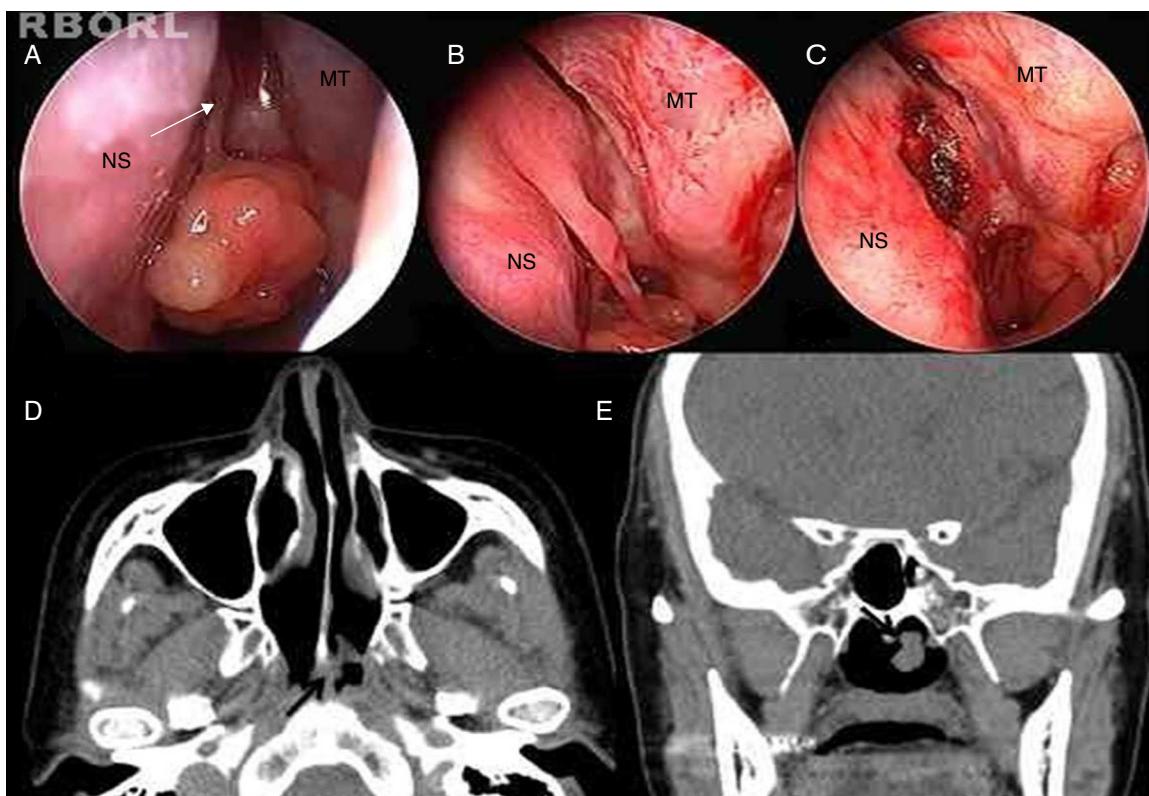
Endoscopic view and PNS CT findings. (A) Close-up view of the nasal polyp based in the left posterior septum (whitish arrow, pedicle; NS, nasal septum, MT, middle turbinate). (B) Pedicle between the nasal polyp and the nasal septum is noted. (C) Postoperative endoscopic appearance shows clear left choana with the pedicle site cauterized on the posteroinferior septum. (D and E) Computed tomography (D, axial; E, coronal) shows the left choanal polyp originating from the septum protruding into the nasopharynx (black arrow, origin site).
